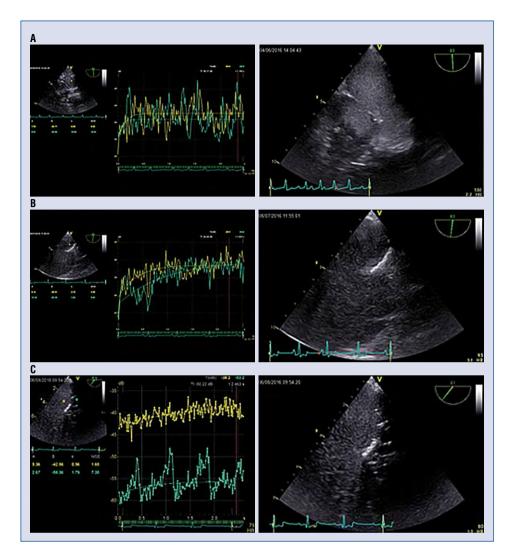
Representative contrast-enhanced transesophageal echocardiography (cTEE) graphs of different score gradings; A. cTEE-score 2: Microbubbles appeared in both left atrium (LA) and left atrial appendage (LAA) simultaneously within 3 heart beats, and fully filled in LAA; both time intensity curves (TIC) for the concentrations in LA (yellow TIC) and LAA (green TIC) were mingled and reached their plateaus at the same time; B. cTEE-score 1: Microbubbles appear slowly in LAA by 3 heart beats after the LA was fully filled with microbubbles; the rising speed of TIC in LAA (green) was slower than the one in LA (yellow), and finally both TICs mixed together although the yellow TIC reached its plateau earlier; C. cTEE-score 0: None visible microbubble in LAA, both TICs were separated with the TIC in LAA lower than that in LA.
